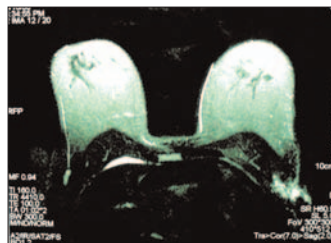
Breast MRI fails to identify the breast origin of the left axillary lymphadenopathy (arrow).
